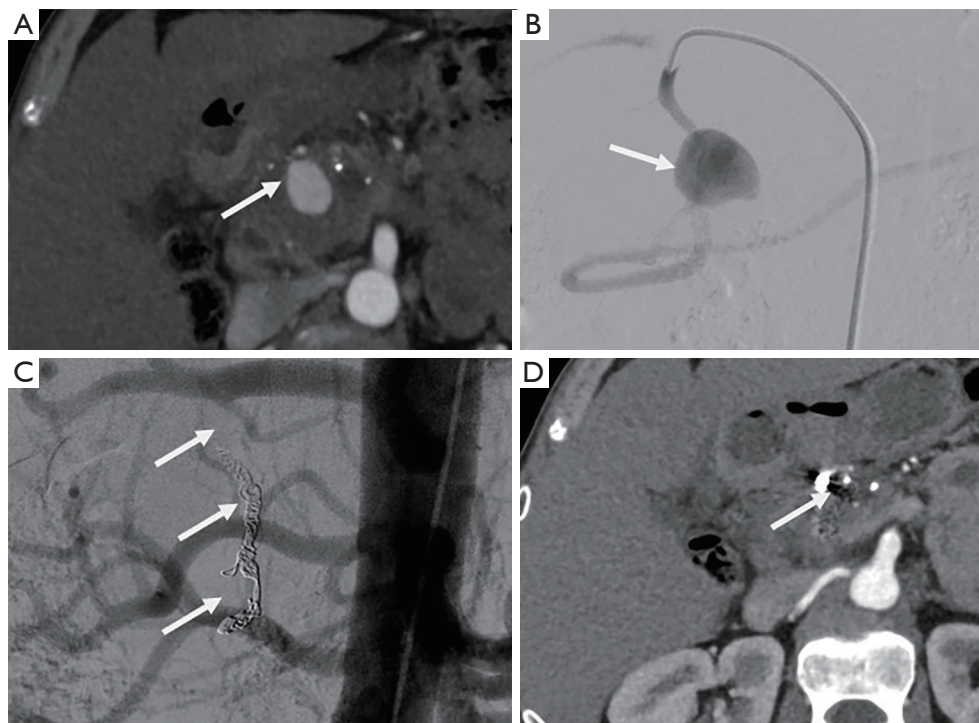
Patient with chronic pancreatitis referred for acute abdominal pain, suggesting acute pancreatitis. (A) Abdominal CT shows a pseudoaneurysm arising from gastroduodenal artery (arrow) without active bleeding. (B) Angiogram in the gastroduodenal artery using a Cobra 4F catheter confirmed VAPA from the gastroduodenal artery, without active bleeding (arrow). (C) Control angiogram after occlusion using front door/back door technique with coils showing no more patency of the pseudoaneurysm (arrows). (D) Control abdominal CT scan showing no more filling of the pseudoaneurysm, which suggests complete thrombosis (arrow). VAPA, visceral artery pseudoaneurysm; CT, computed tomography.
